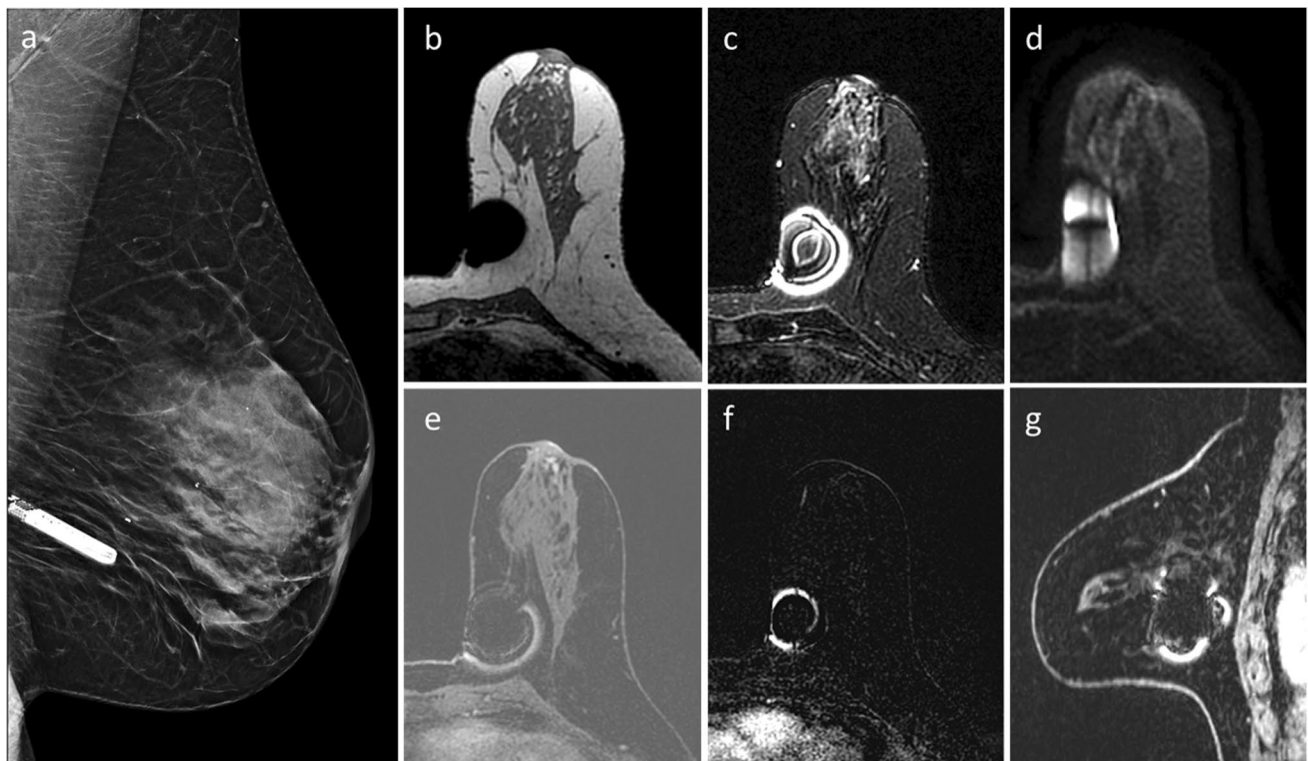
Loop recorder artifact appearance on the various MRI sequences. Images of a representative 64-year-old patient with implantable loop recorder. Left breast mammographic medio-lateral oblique (MLO) view reference (a) highlights the relatively small dimensions of the device and its position at the lower-inner breast. Non-fat-suppressed pre-contrast T1-weighted image reveals signal void in the device bed (b). High signal void artifact is demonstrated
